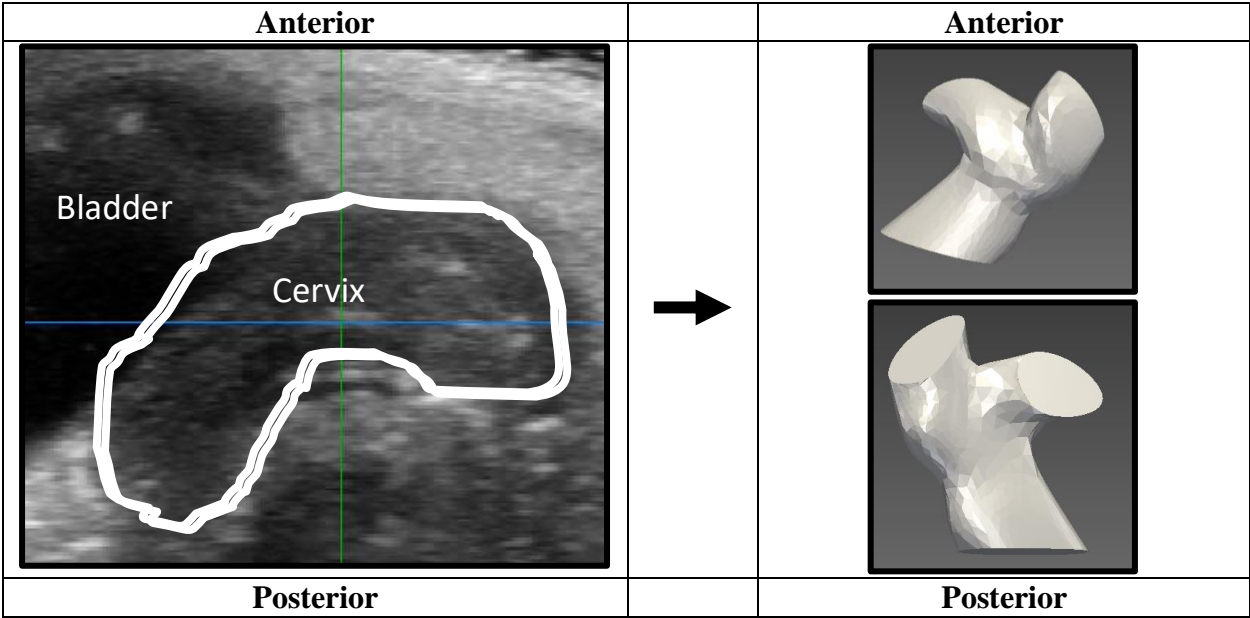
From volumetric data gathered on the ultrasound to creating 3D models on SimVascular, this demonstrates how multiple slices of these images can create an accurate representation of the cervix and the uterine horns.
